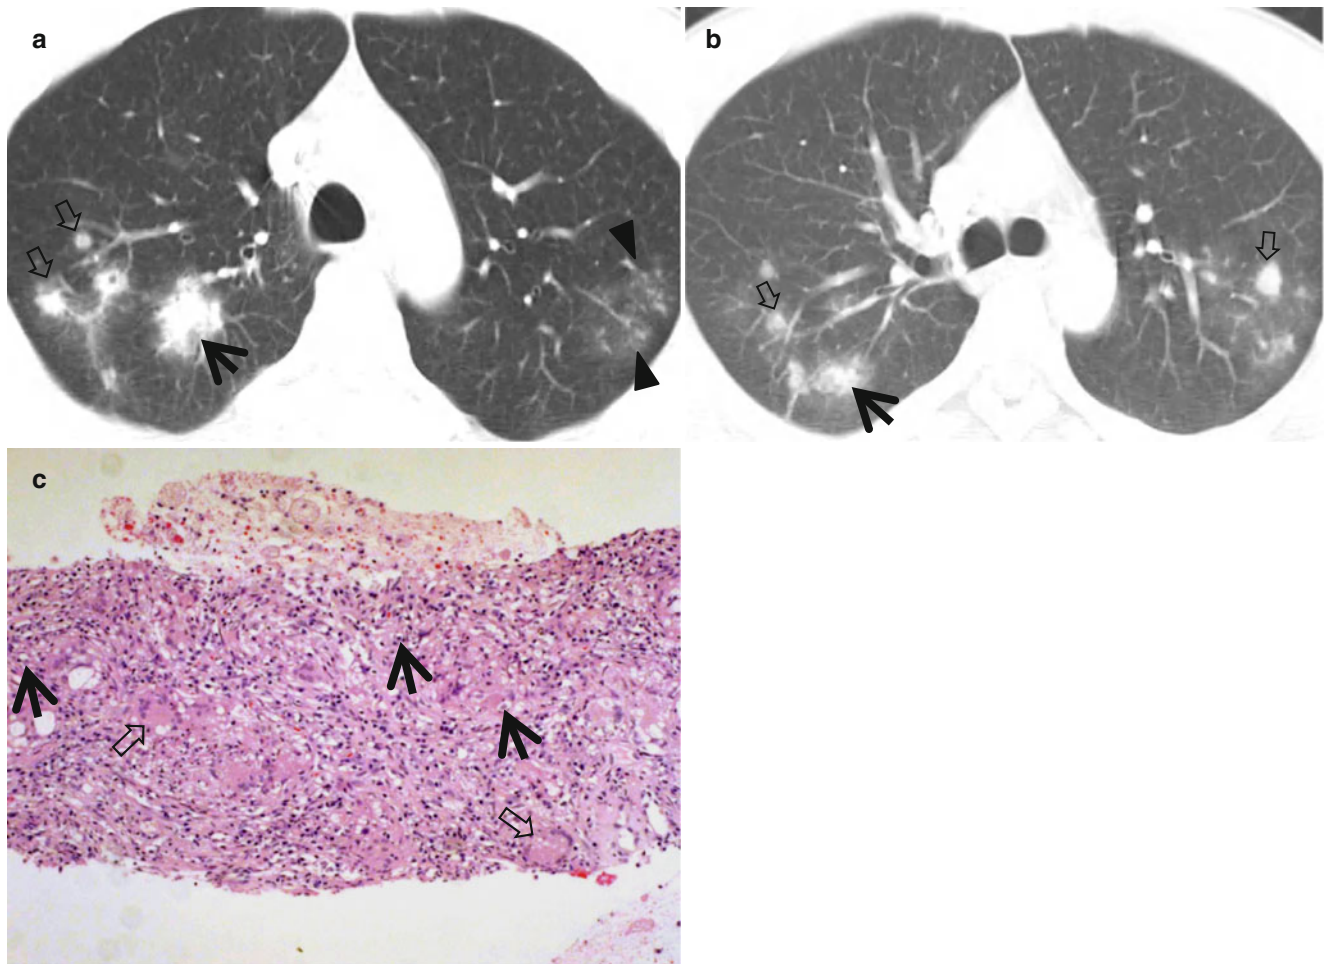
Pulmonary cryptococcosis appearing as patchy areas of consolidation, poorly defined nodules, or nodular branching lesions in both lungs in a 37-year-old man. (a, b) Lung window images of CT scans (5.0-mm section thickness) obtained at levels of the aortic arch (a) and main bronchi (b), respectively, show patchy areas of poorly defined nodules (arrows), areas of consolidation (open arrows), and tree-in-bud
